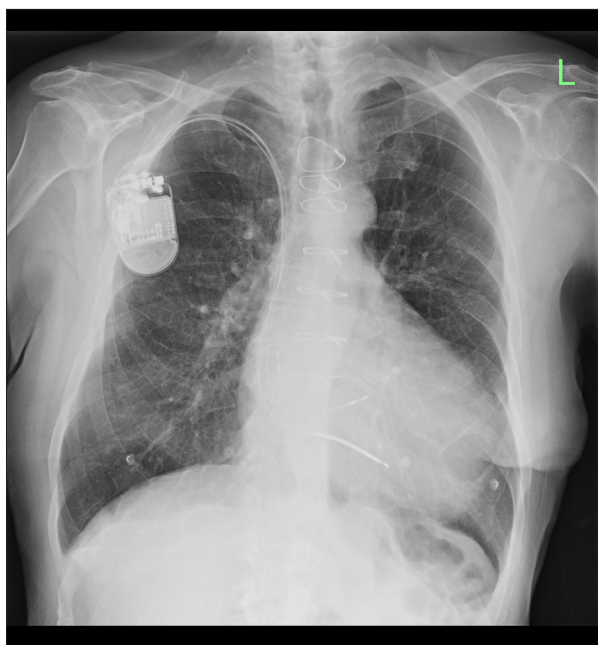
Final perioperative X-ray image with confirmed lead positions. The final fluoroscopic image after implantation of the implantable cardioverter defibrillator system with left bundle branch area pacemaker stimulation demonstrates stable positioning of the left bundle branch area pacemaker lead within the interventricular septum, consistent with effective conduction system capture. The implantable defibrillator lead remains optimally placed in the apical septum, and the right atrial lead shows appropriate fixation. This final radiograph confirms correct depth and orientation of the left bundle branch area pacemaker lead, ensuring reliable physiological pacing and anticipated resynchronization.
